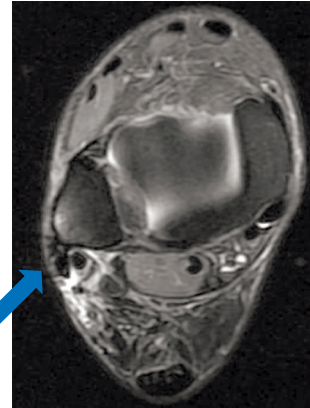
MRI image demonstrating lateral position of peroneal tendons with tenosynovitis
